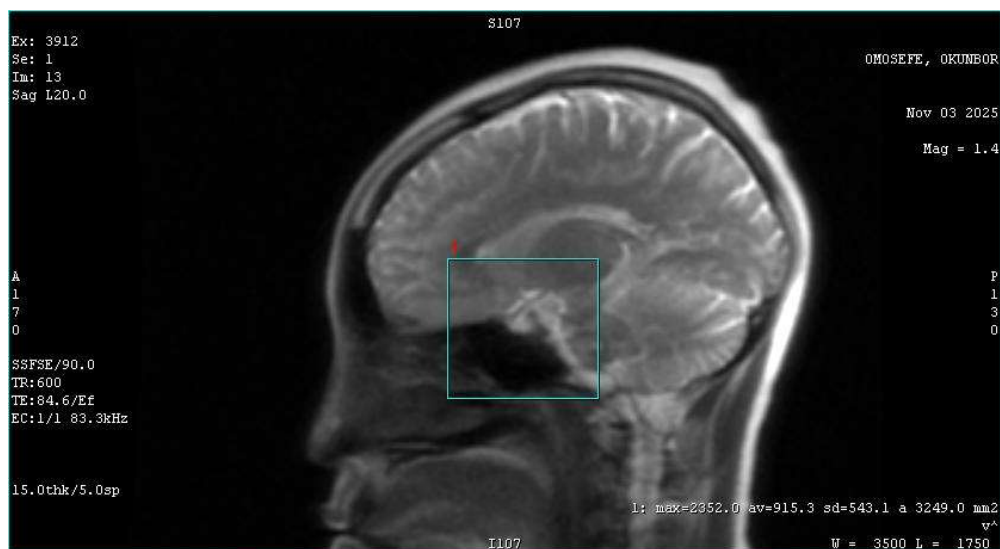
Sagittal T2-weighted SSFSE MRI (slice thickness 15 mm, Series 1, Image 13) demonstrating an empty sella configuration. The sella turcica is occupied by cerebrospinal fluid-intensity signal (T2-hyperintense) with no identifiable pituitary parenchyma, consistent with pituitary involution following postpartum haemorrhage in Sheehan's syndrome. The cyan box highlights the sellar region of interest. Note: dedicated pituitary-protocol thin-section MRI (2–3 mm) was not available at the study centre; the infundibulum sign could not be resolved at this slice thickness.
